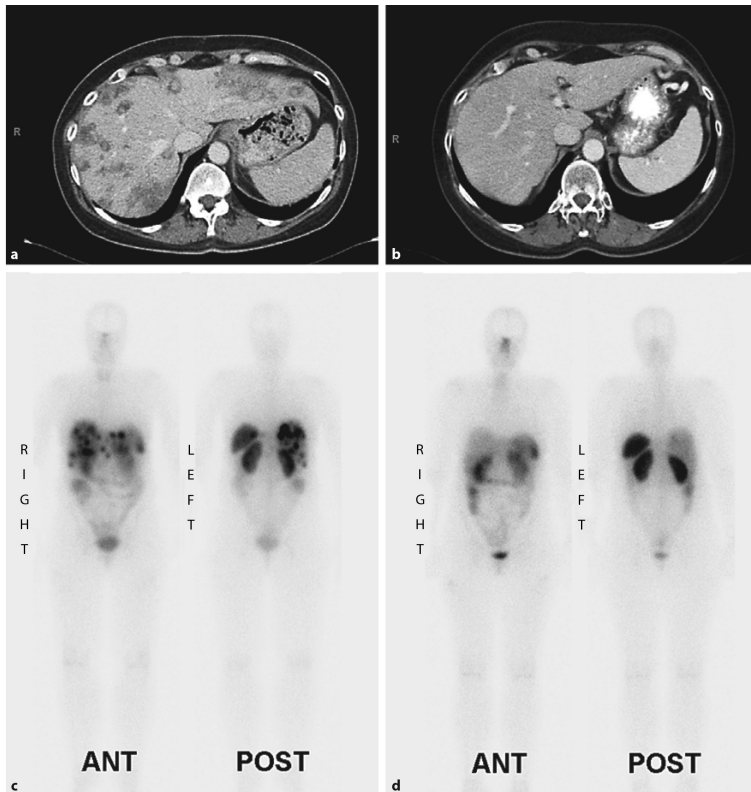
PR in a patient with an insulinoma with liver metastases treated with 29.6 GBq (800 mCi) ^{177}Lu -DOTATATE. (A) CT scan showing multiple liver metastases of an insulinoma before treatment with ^{177}Lu -DOTATATE. (B) CT scan 6 weeks after treatment with ^{177}Lu -DOTATATE, showing regression of liver metastases, consistent with a PR. (C) Post-therapy scan of the same patient after the first treatment with ^{177}Lu -DOTATATE, showing intense uptake in multiple liver metastases. (D) Post-therapy scan after the fourth (and last) treatment with ^{177}Lu -DOTATATE, showing reduced uptake in liver metastases. ANT: anterior; POST: posterior.
